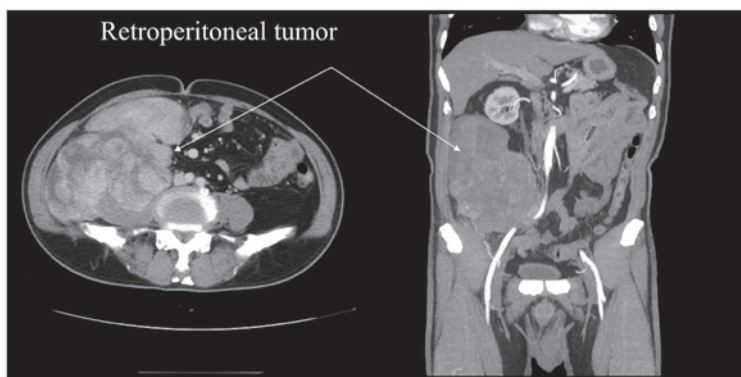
Abdominal computed tomography scan prior to mesna, tetrahydropyranil adriamycin, ifosfamide and dacarbazine treatment. The tumor measured ~20x12x8 cm and was situated in the retroperitoneum. The tumor caused right internal, external iliac arteries and right ureter medial displacement, mild hydronephrosis and hydroureter.
